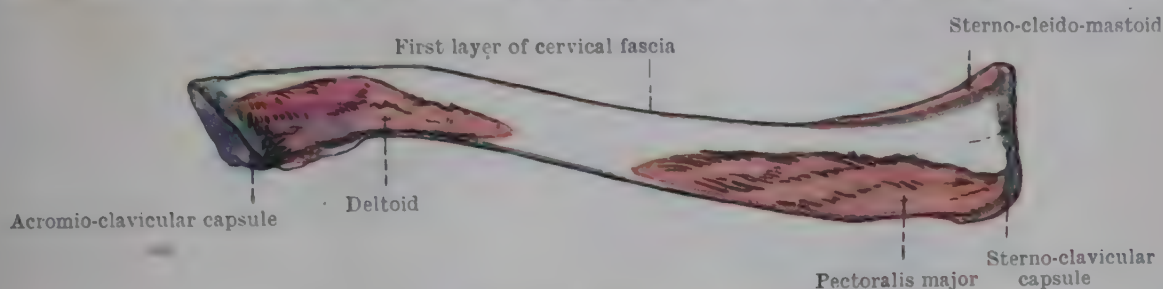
ANTERIOR ASPECT OF RIGHT CLAVICLE.
